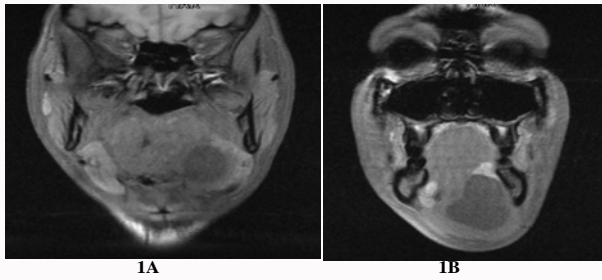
MRI scans (T1-weighted imaging): shows cystic lesion (Figure 1A) with low signal intensity above the mylohyoid muscle (Figure 1B) with a maximum diameter of 5.7 cm.
